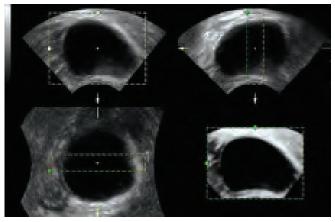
Three-dimensional ultrasound image of a simple ovarian cyst. Only cysts without papillary protrusions and septa can be treated by transvaginal ultrasound-guided aspiration
